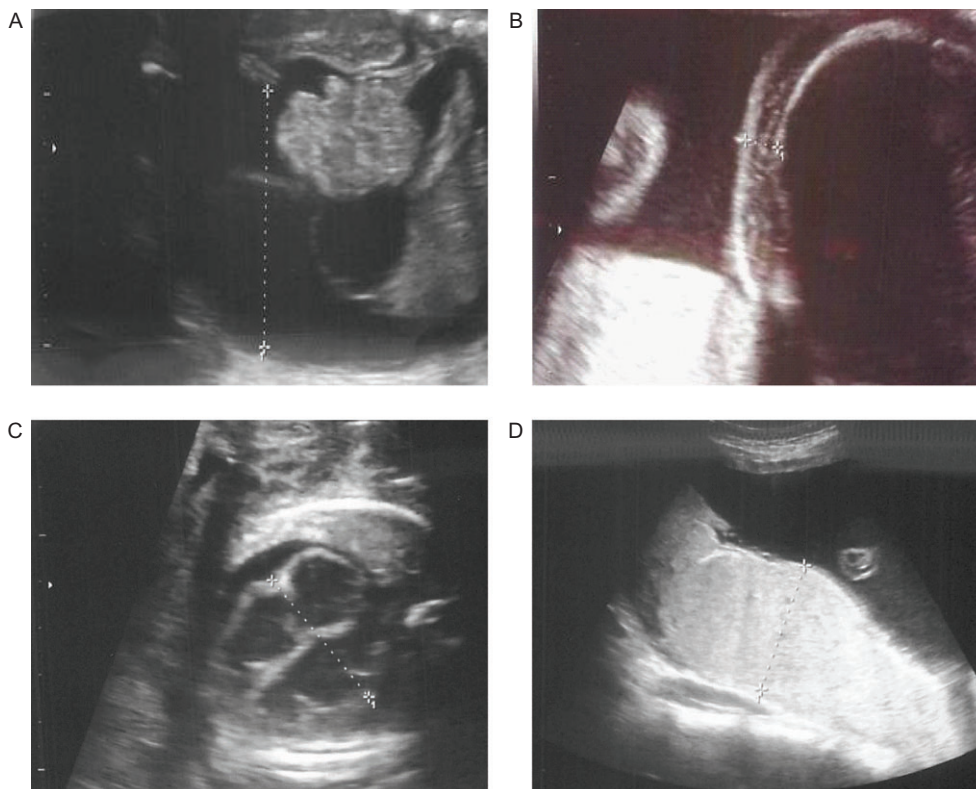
Fetal ultrasound test on the admission day. Massive ascites (A), subcutaneous edema (B), pericardial fluid (C) and placental hypertrophy (D).
